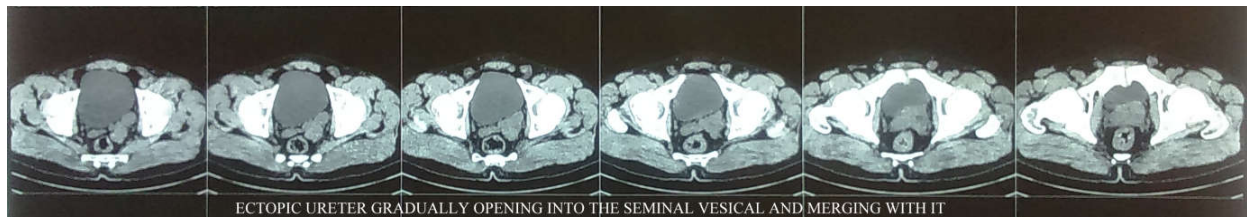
CT image showing close association of ectopic ureter and seminal vesical
